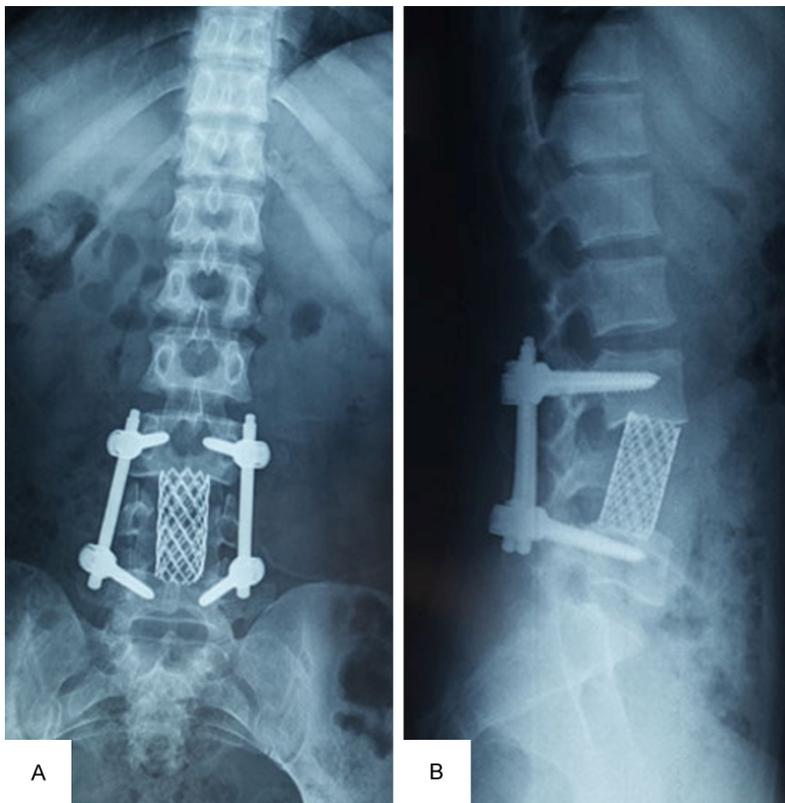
Postoperative X-rays (A, B) demonstrate that the instrumentation was in good position, with some degree of lumbar lordosis.
